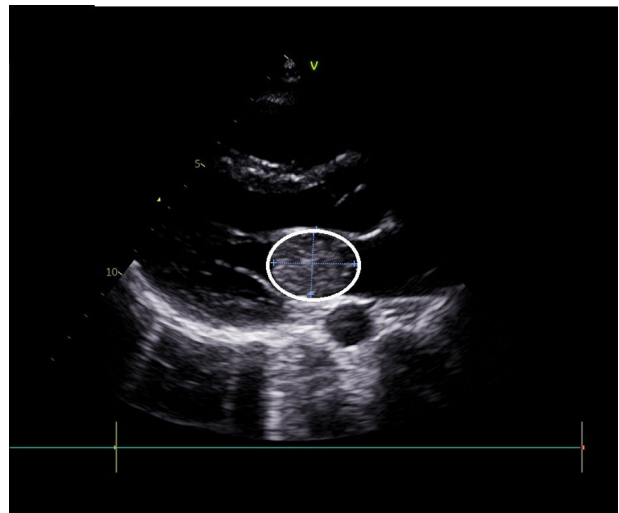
Echocardiogram showing left atrial myxoma (white circle) measuring 33 mm × 27 mm.
